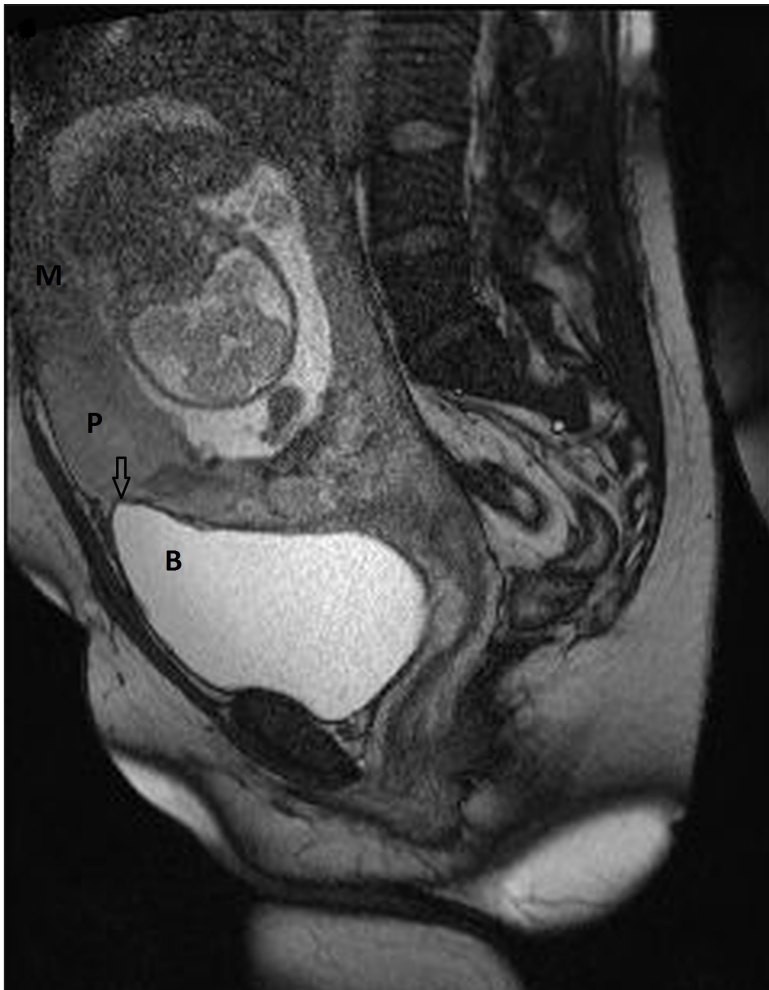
Sagittal T2-weighted MR images. The upper wall of the bladder (B) is locally deformed from the left to 35 mm in length, contact and pressing (arrow) from the side of the placenta (P) is visible, in some places the wall contour of the bladder of the normal signal is clearly differentiated and hypervascular, inadequate myometrium (M)
